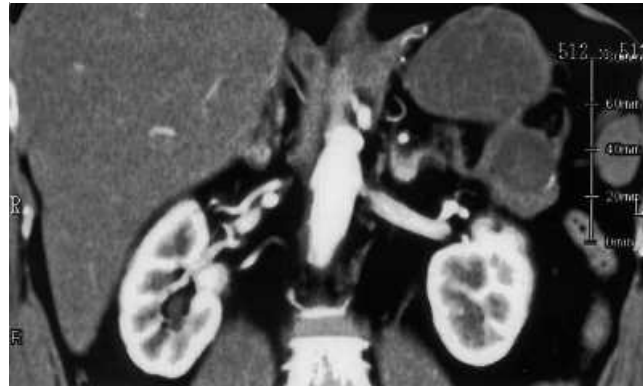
Abdominal computed tomography showing a thrombotic aneurysm of the splenic artery.
